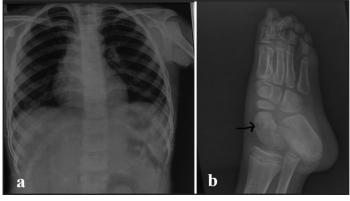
(a) X-ray chest of a child to rule out the pulmonary tuberculosis. No abnormal lesion visualised; (b) X-ray lateral view of the right ankle showing cystic TB lesion of Talus (black arrow).
